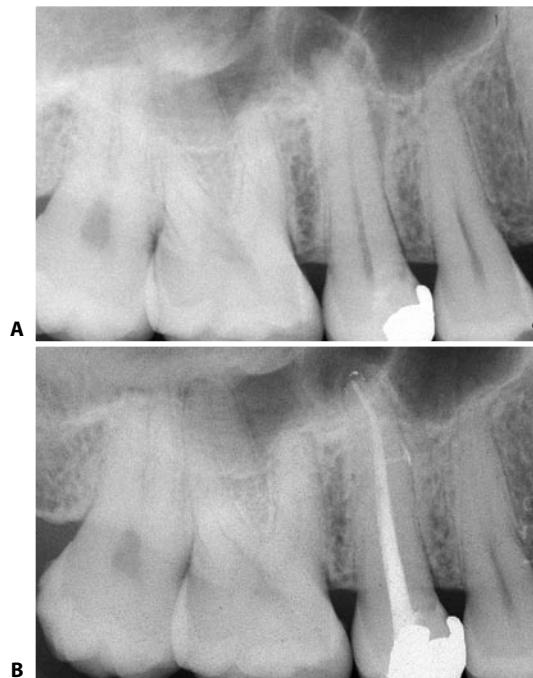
A, B. Pre-op and 24 month recall radiographs of an upper premolar filled with the Continuous Wave of Condensation. Note the multiple lateral canals filled in the apical thirds of these curved canals despite the narrow coronal GT File shapes (Courtesy of Dr. A. Castellucci).
